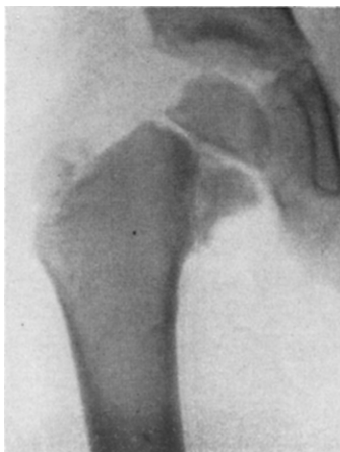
Case xvii. Roentgenogram December 10, 1931; necrotic subcapital segment separated but not displaced.
